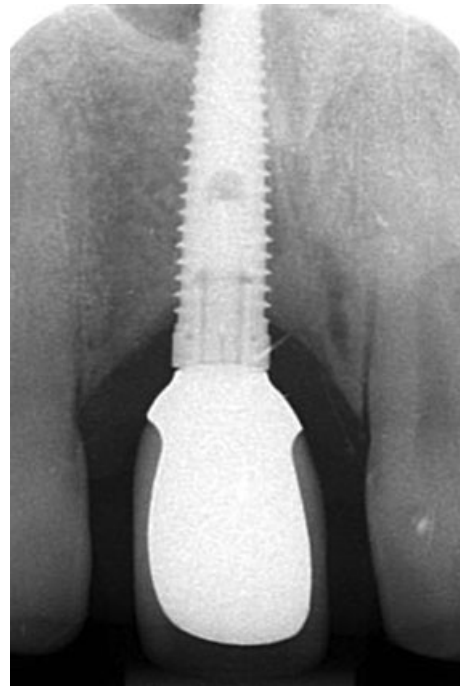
Radiographic view after trauma. Note the small triangular gap at the distal implant-abutment interface.
